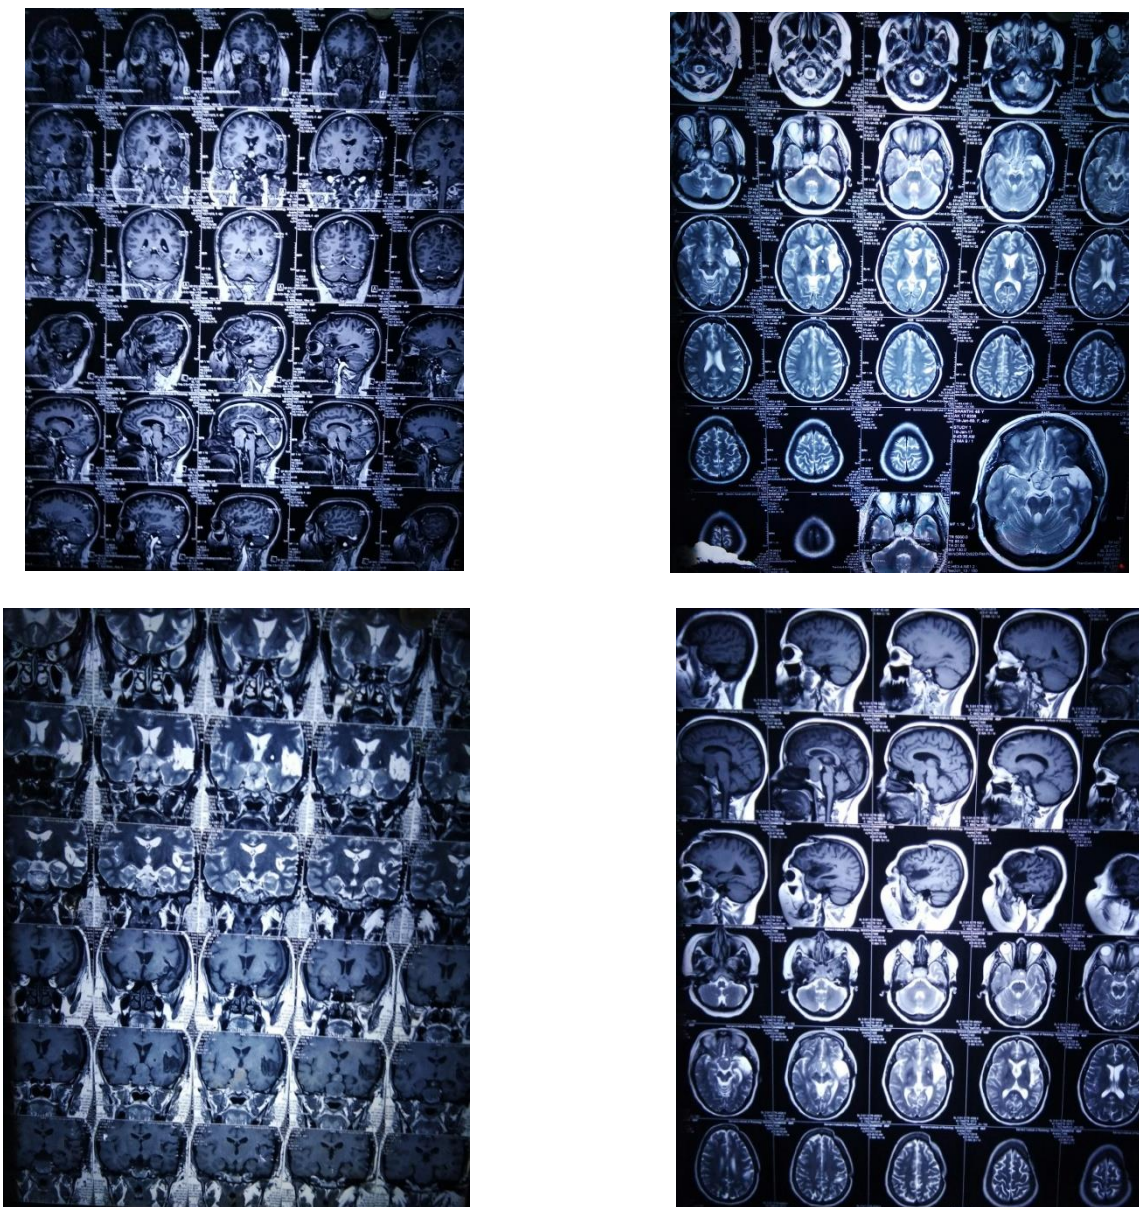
MRI scan of the patient before excision of the tumor
